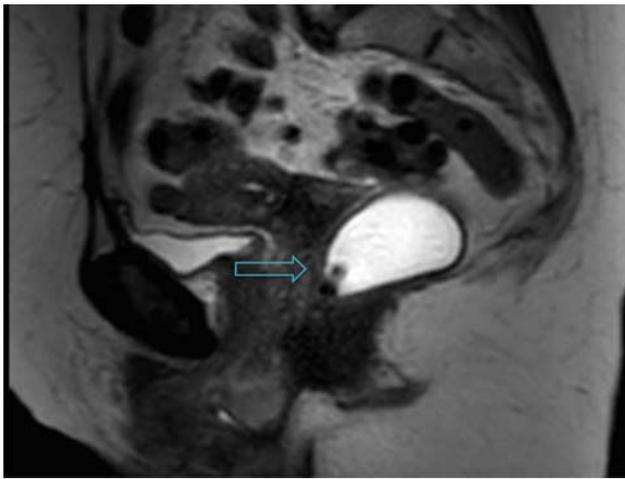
Sagittal view of pelvic MRI showing a heterogeneous mass encasing the distal urethra. (Color version available online.)
